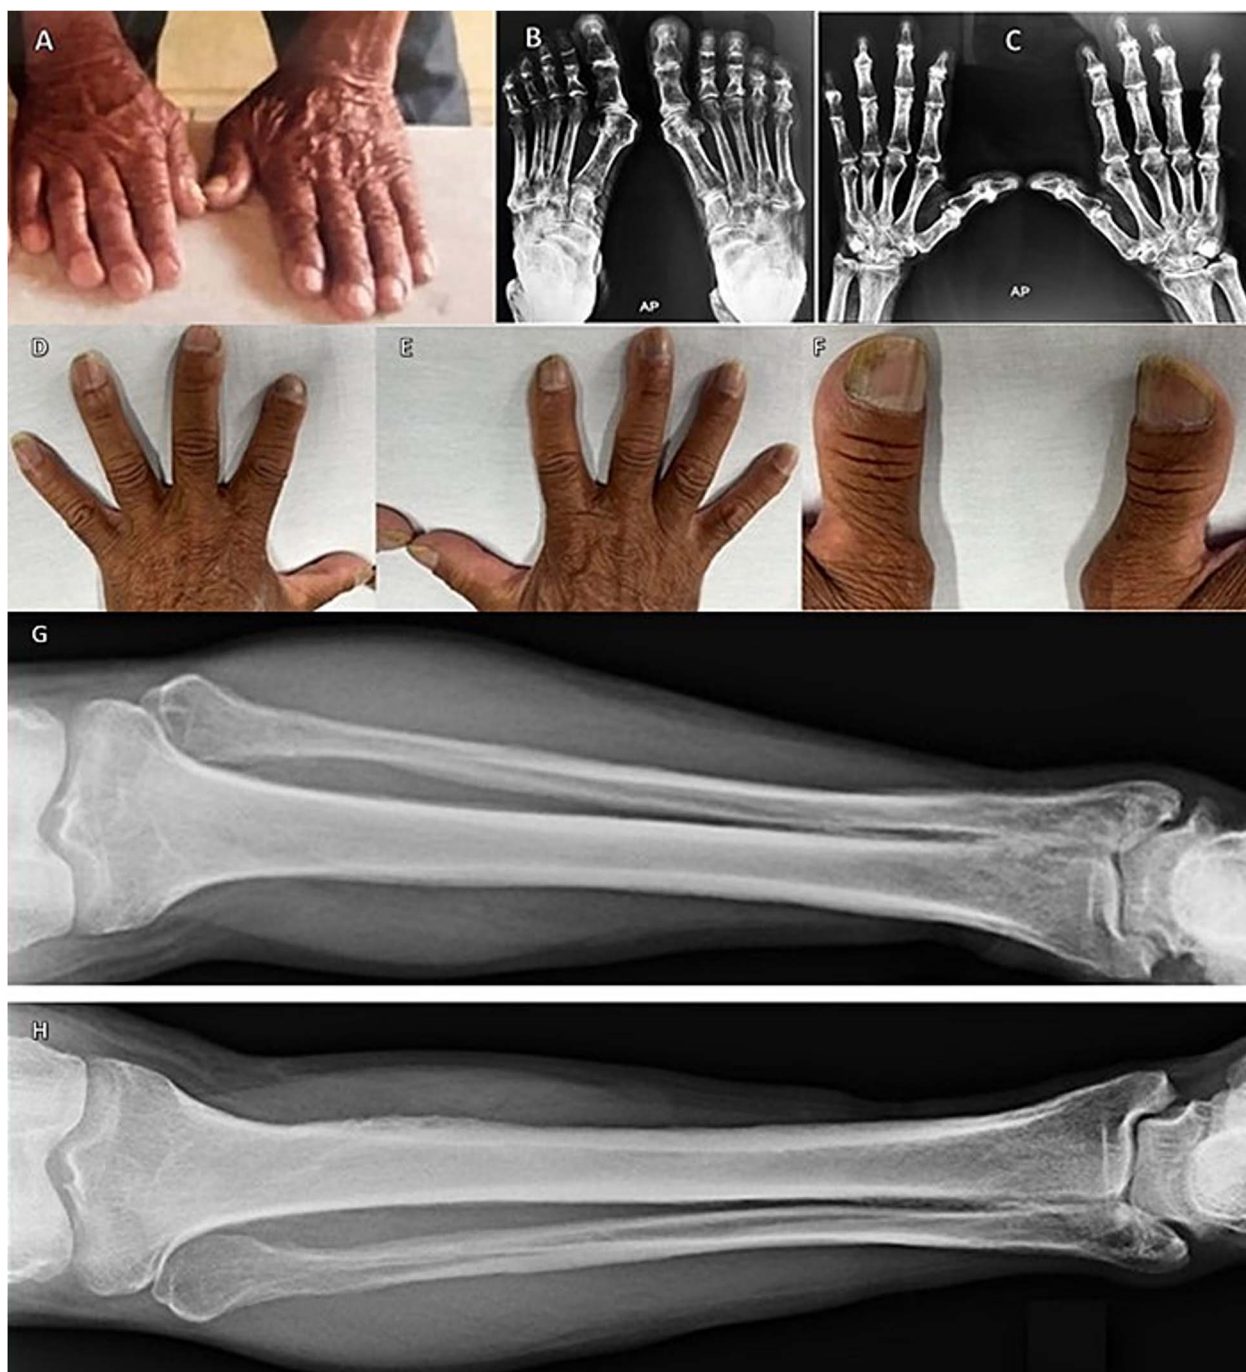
A: Index case 2's father showing moderate digital clubbing of the third, fourth, and fifth digits of the right hand and mild clubbing of the second and third digits of the left hand. B and C: Index case 2's mother: Radiographic image showing mild periosteal reaction present in the hands and feet associated with pachydermia. D–H: Index case 3's father showing mild clubbing of the second and third digits of the left hand (D); mild digital clubbing of the third, fourth, and fifth digits of the right hand (E); enlargement of the first digit of both hands, suggesting periostosis (not confirmed by radiography) (F); and evident periostitis in both tibiae and fibulae (G and H).
